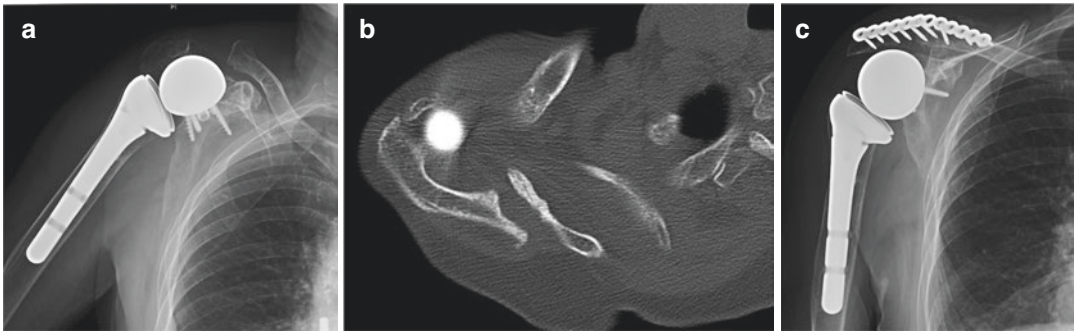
A 70-year-old woman with rheumatoid arthritis is presented. RSA was performed to relieve her pain and loss of motion due to her disease. The patient underwent knee and spine surgeries as well due to her disease. She was performing well with the RSA, until suddenly she started experiencing loss of motion and pain in her right shoulder. In this scenario, an X-ray was performed where we can find
